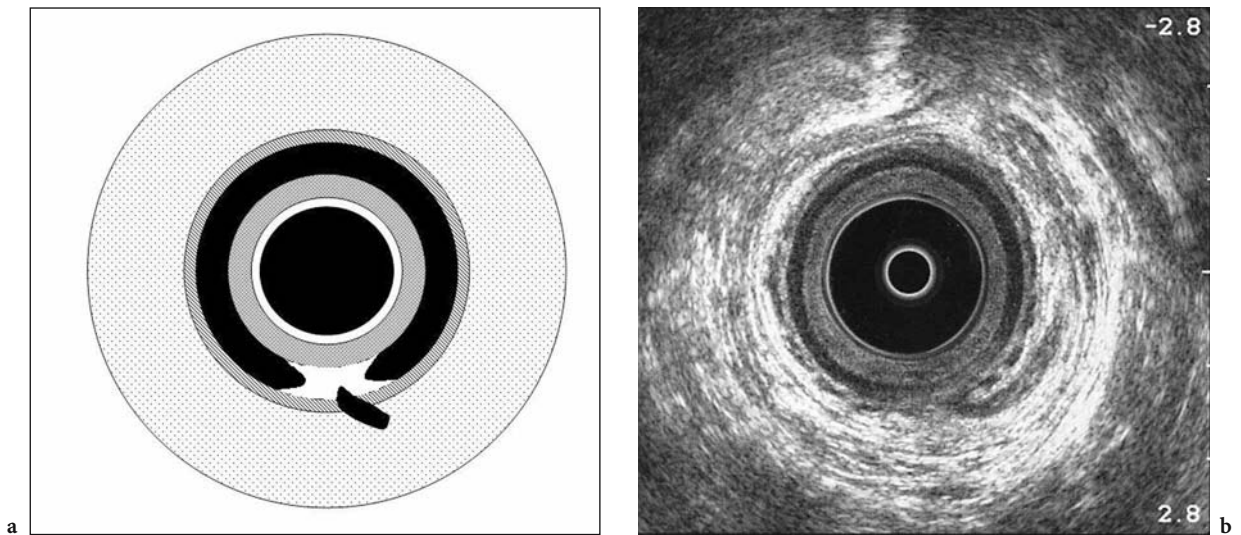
Second endosonographic criteria for the site of an internal opening according to Cho [17]: a root-like budding with an appearance of internal sphincter defect due to inflammatory changes within the sphincter increasing its reflectivity locally (a, b)
